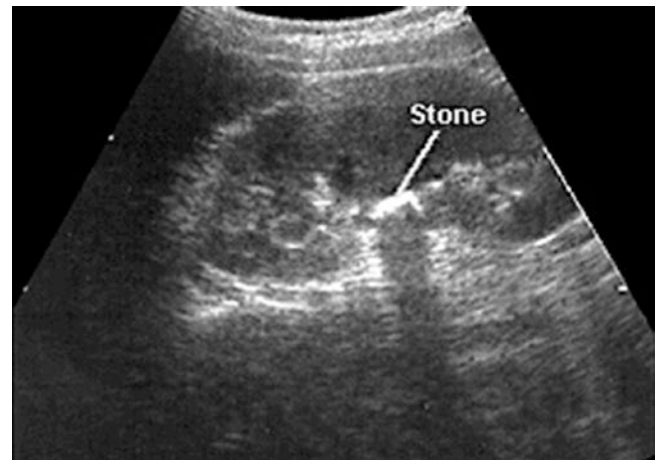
Ultrasound image of a stone in the renal medulla. Though seen with less sensitivity than hydronephrosis, kidney stones can also be visualized in the collecting system. They appear as hyperechoic structures 1–15 mm in size, which cast a posterior shadow. (Image courtesy of Bret Nelson.)
